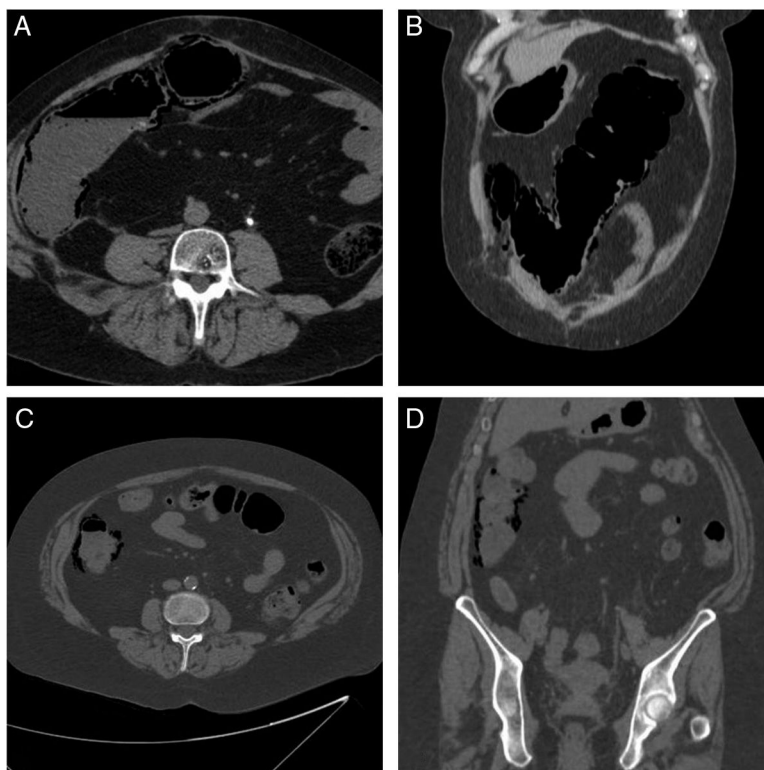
Case 1: axial (A) and coronal (B) slices from the abdominal and pelvic CT scan without contrast medium in which extensive pneumatosis intestinalis is observed in the ascending and transverse colon. Case 2: axial (C) and coronal (D) slices from the abdominal and pelvic CT scan without contrast medium in which pneumatosis intestinalis limited to the ascending colon is observed.
